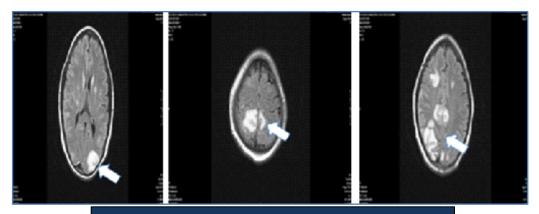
Cranial MRI of the patient with eclampsia showing various areas of cerebral involvement
